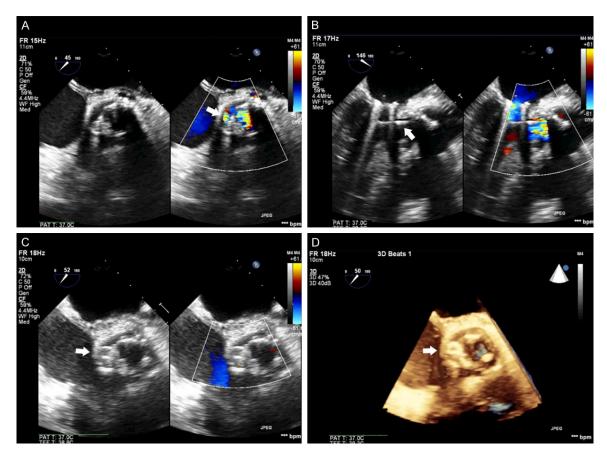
Transesophageal echocardiography (TEE) guidance of percutaneous aortic paravalvular leak (PVL) closure. A. TEE shows the aortic paravalvular leak (arrow). B. Delivery of catheter across PVL (arrow). C. Amplatzer Duct Occluder in place (arrow). D. Real-time 3D TEE shows the occluder in place (arrow).
